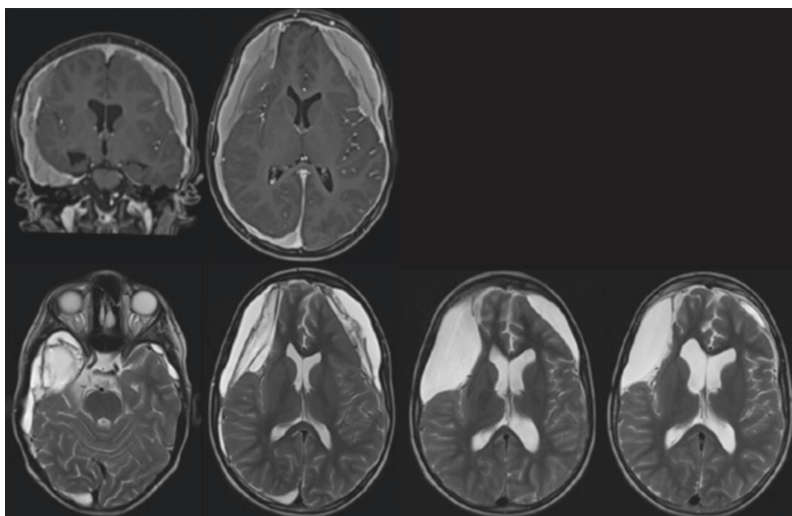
The T1-weighted MR images in axial and coronal view show bilateral subdural chronic hematoma in a 9-year-old boy who experiences repetitive minor head trauma (upper row). Obviously, the right temporal AC ruptured and caused chronic bleeding into the subdural space over both hemispheres. After simultaneous irrigation and drainage of the subdural hematomas as well as fenestration of the AC, subdural hygromas became smaller over a period of 12 months (lower row)
